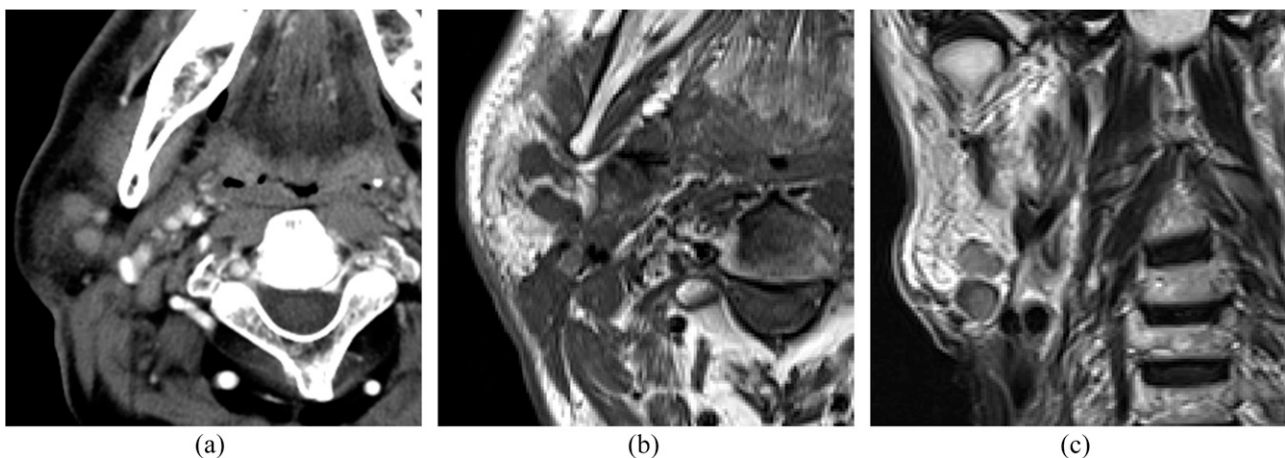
A 70-year-old male with metastases to the parotid nodes from squamous cell carcinoma of the larynx: (a) an axial post-contrast CT image is showing multiple homogeneous enhancing masses in the parotid tail. (b, c) Axial T_1 weighted (b) and coronal T_2 weighted (c) images are showing multiple well-defined masses in the parotid tail.
